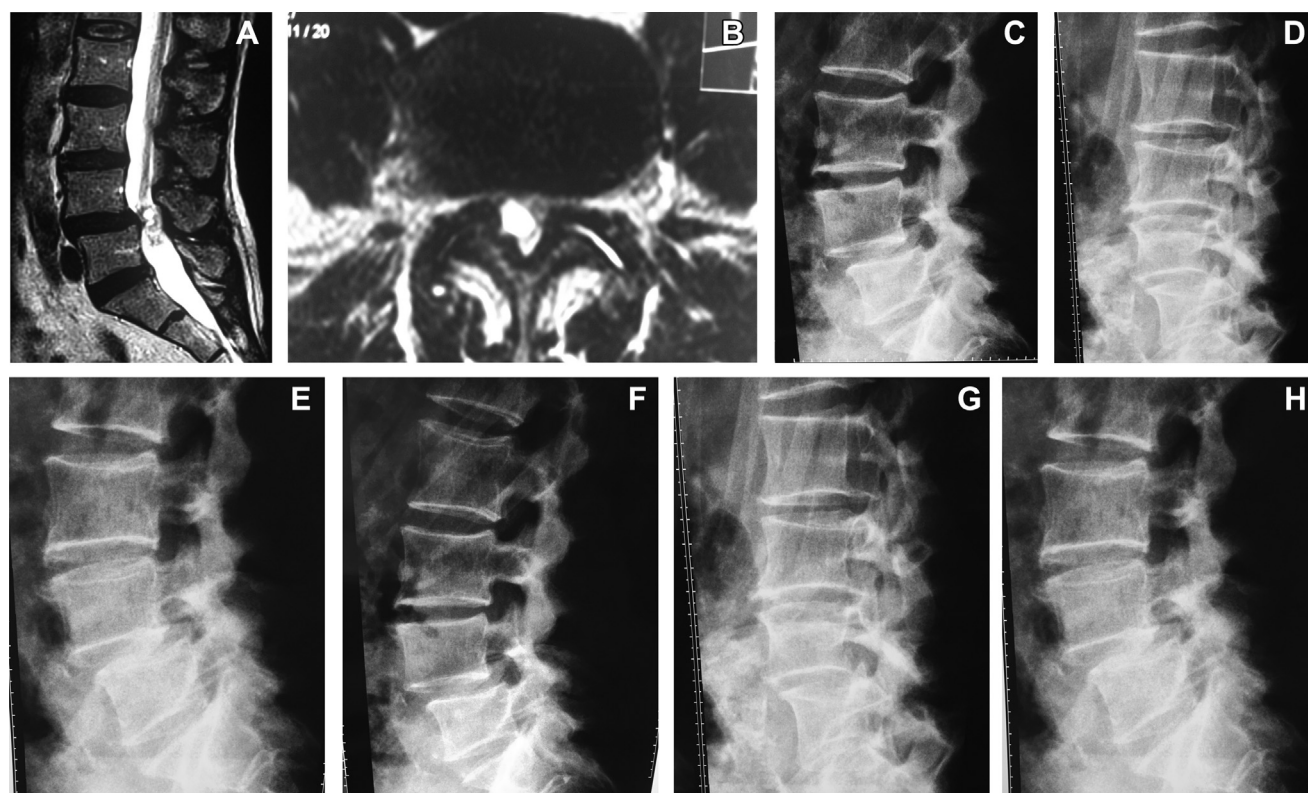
(A) Sagittal T2-weighted magnetic resonance image demonstrating a synovial cyst at L4-L5 with grade 1 spondylolisthesis. (B) Axial T2-weighted image showing the synovial cyst arising from the right facet joint. Preoperative lateral X-rays: (C) static, (D) flexion, and (E)
